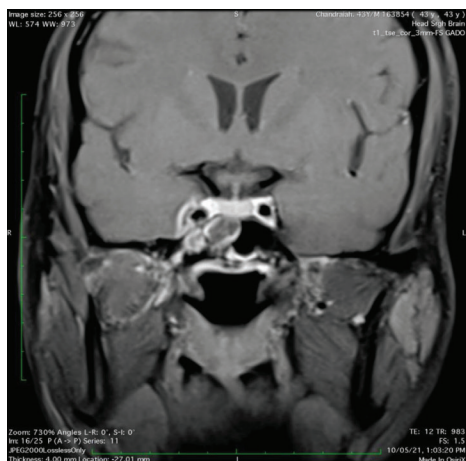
Coronal CE T1 weighted MRI image in case of Mucormycosis showing mild enlarged right cavernous sinus with patchy heterogenous enhancement.
